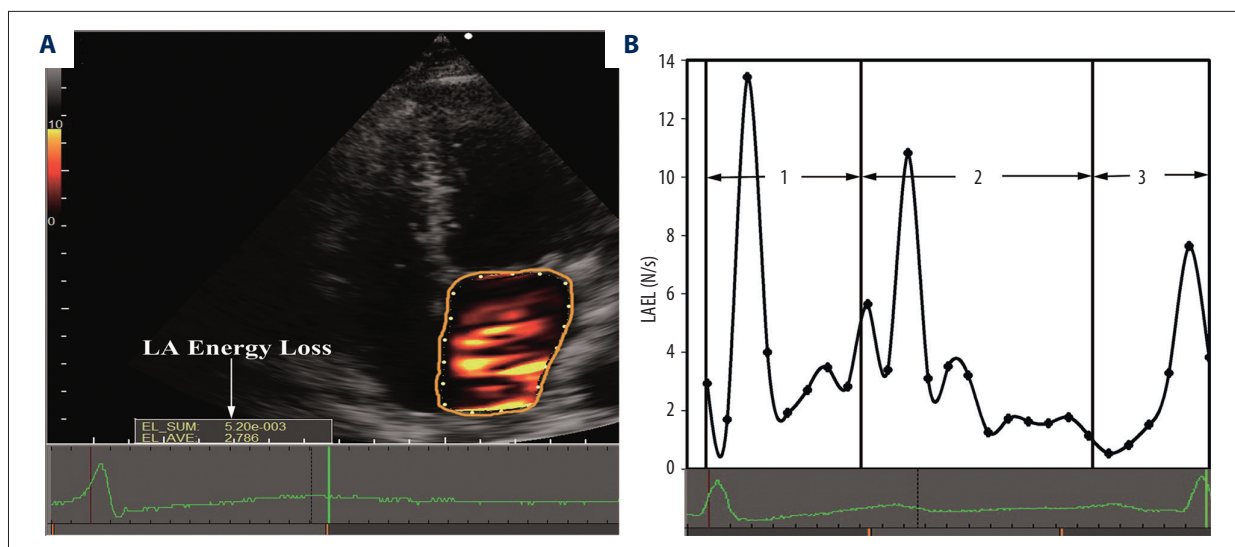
LA energy loss was analyzed at the apical four-chamber view. After the region of interest was determined by tracing, the distribution of EL could be displayed in two dimensions (A). Panel (B) is the LA energy loss change during one cardiac cycle, and we divided the whole cycle into three phases, where 1 represent ventricular systole (from the peak of the R wave to the onset of the T wave); 2 represents early diastole (from the onset of the T wave to the onset of the P wave); and 3 represents atrial contraction (from the onset of the P wave to the peak of the R wave).
